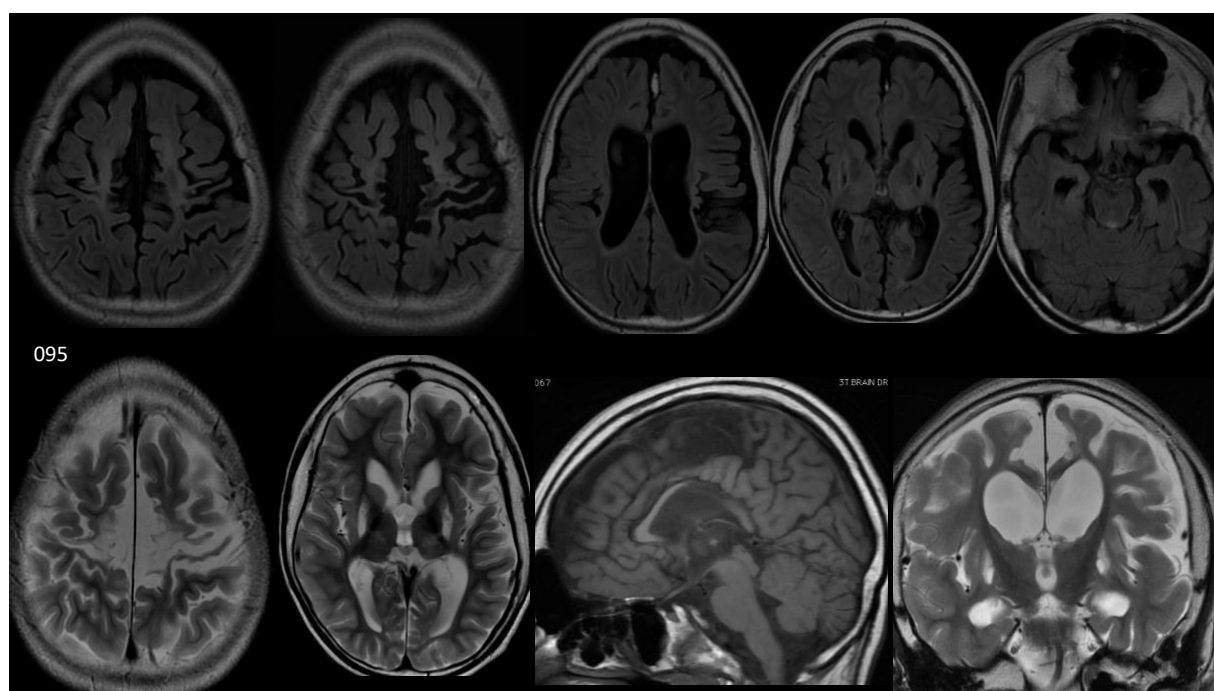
Collage of MRI images obtained for patient 095
